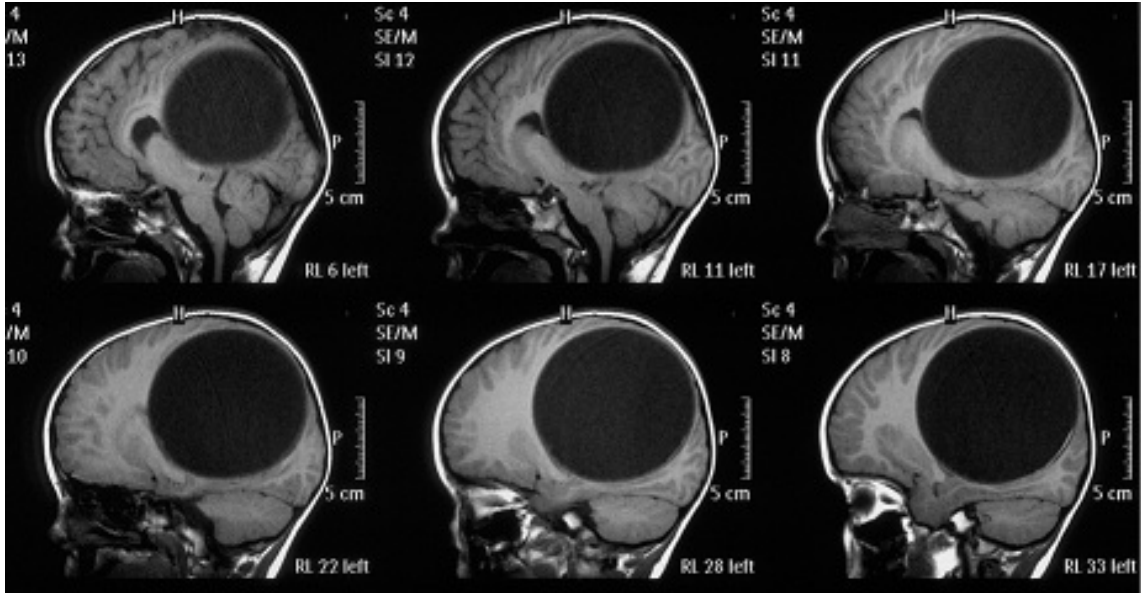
Preoperative MRI- T2 weighted images, sagittal sections shows the compression of corpus callosum
